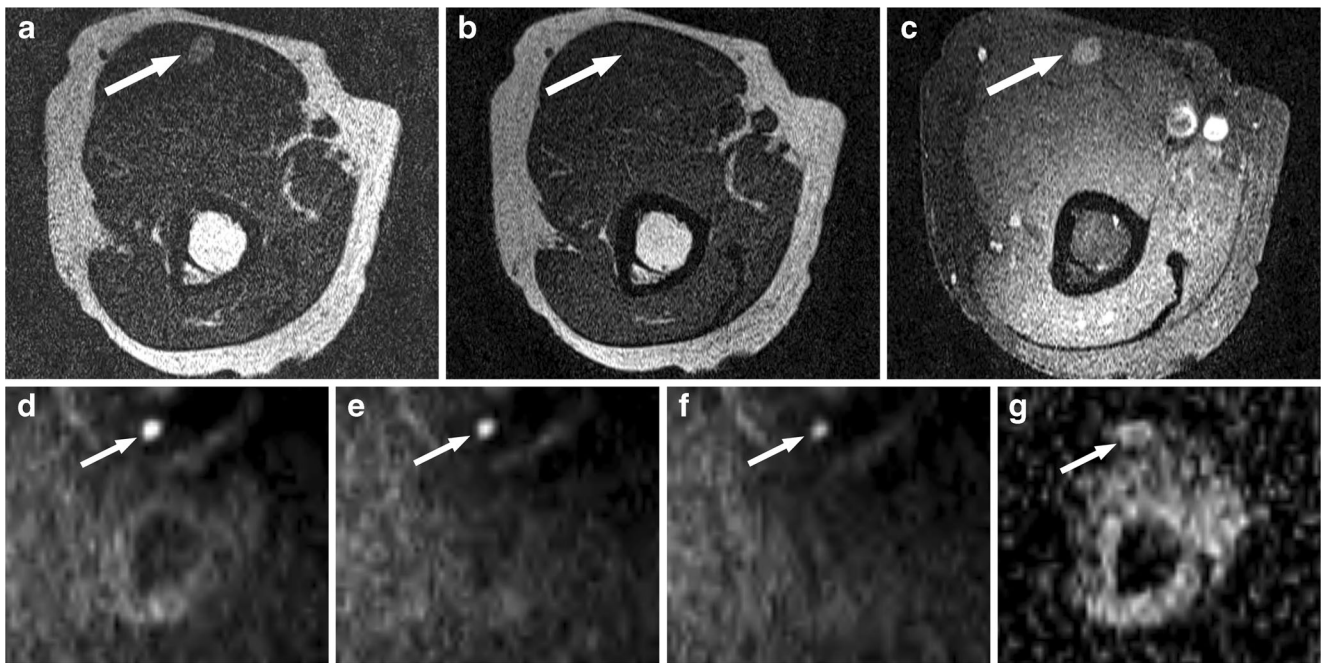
A 70-year-old woman with malignant melanoma in the upper arm. Both readers interpreted the mass as indeterminate lesion (score 2) during the first step. Interpretation was correctly changed during the second step by both readers. (a, b, c) There is a well-defined ovoid lesion (arrow) within biceps brachii muscle with intermediate to hyperintense signal on T2-weighted image (a, TR/TE 4000/63) and hypointense signal on T1-weighted image (b, 730/13), which shows relatively homogeneous enhancement on fat-suppressed contrast-enhanced T1-weighted image (c, 700/15). During the first step standard MRI was interpreted as
